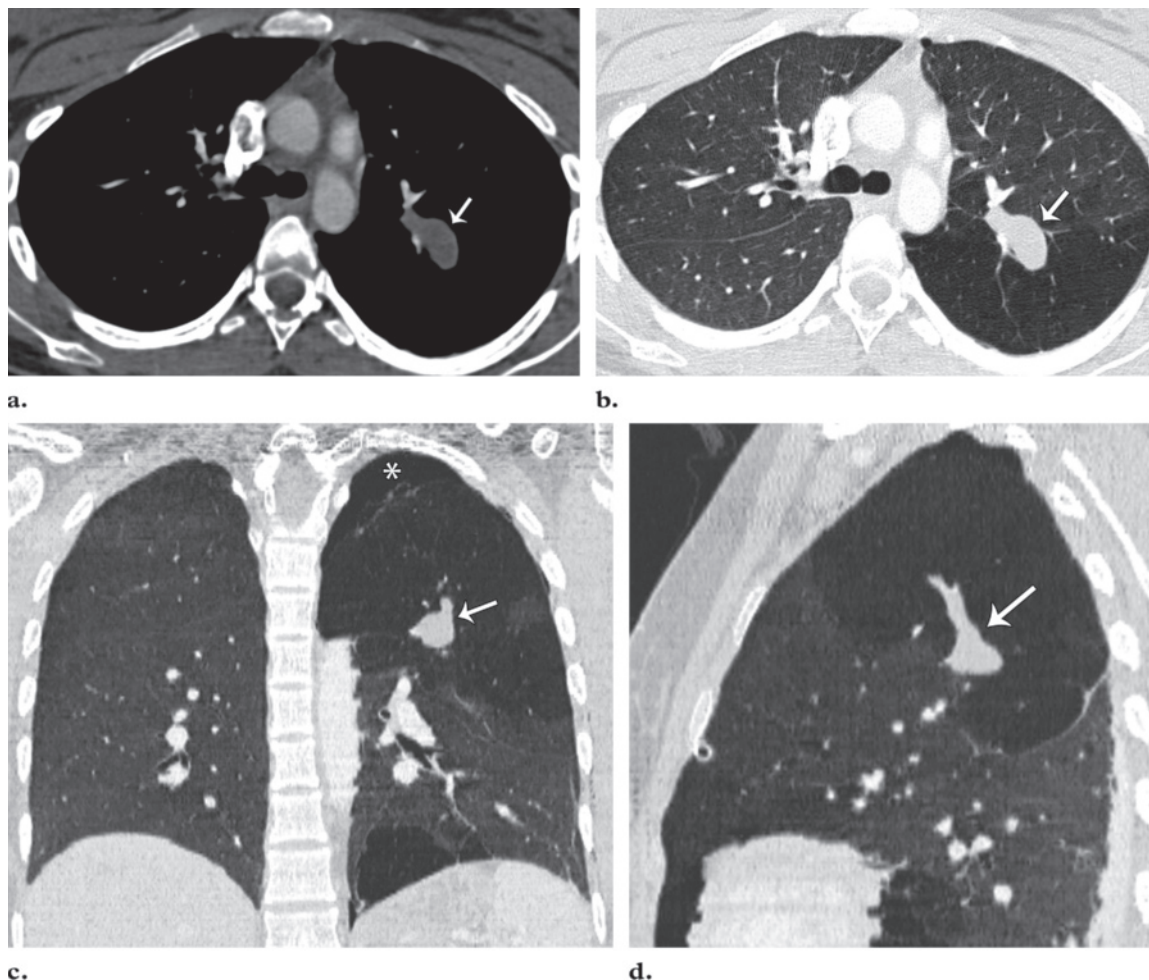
Axial soft-tissue window (a), axial lung window (b), and minimum-intensity-projection lung window coronal (c) and sagittal (d) contrast-enhanced CT images show a tubular nonenhancing lesion (arrow), a finding consistent with mucus impaction of the apicoposterior left-upper-lobe bronchus (bronchocele). Decreased attenuation is seen throughout the apicoposterior segment of the left upper lobe in b–d, a finding indicative of associated air trapping. These CT features are diagnostic of bronchial atresia. Note the small residual pneumothorax (*) in c).
